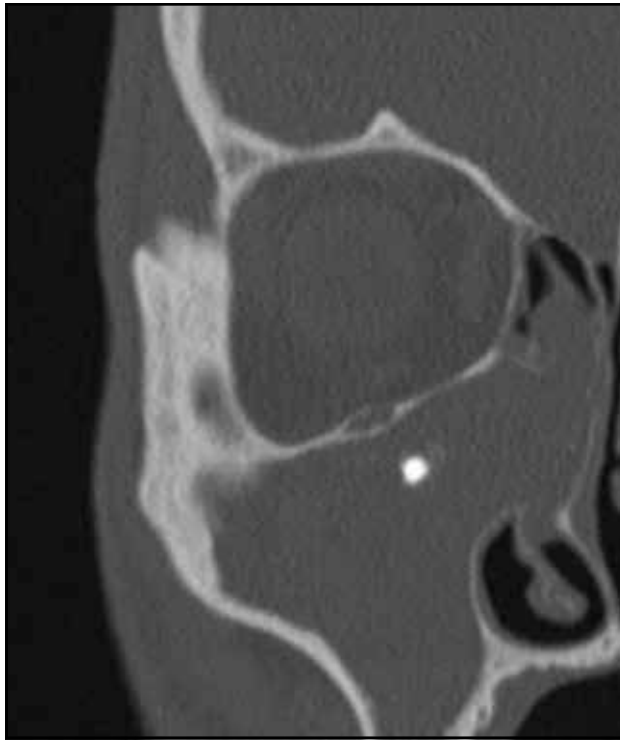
Iatrogenic sinusitis - cranio-facial CT scan (axial slice).
